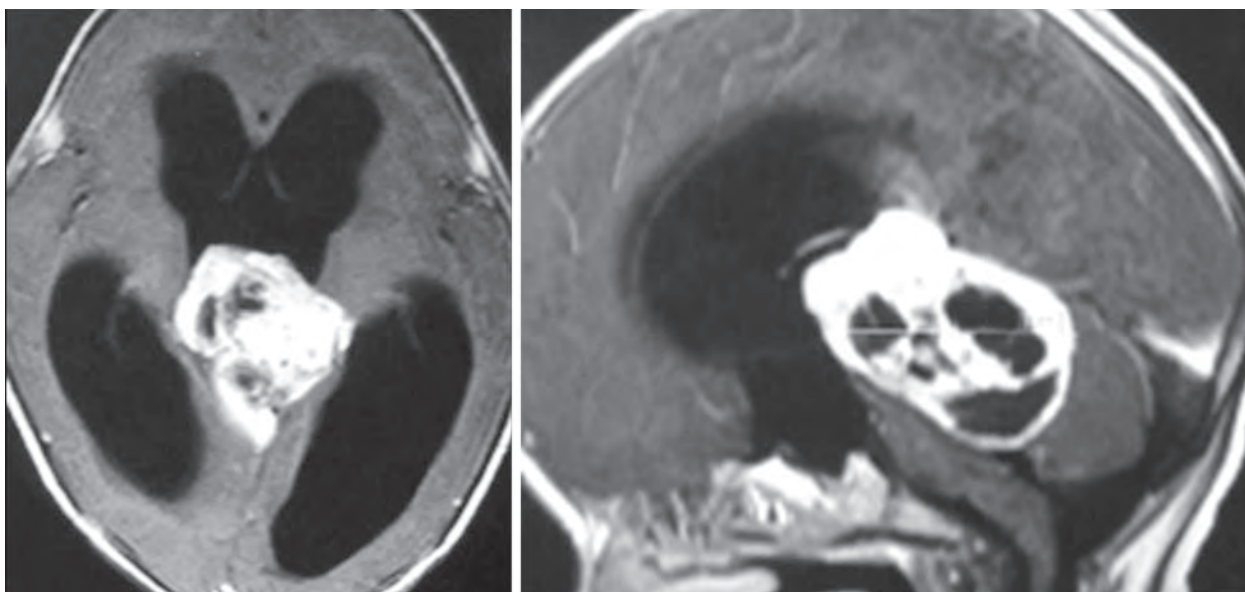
A 1¼ -year-old baby presented with vomiting and loss of walking ability. MRI showed a richly enhancing large mass in the pineal region with necrotic areas. The serum AFP was 225 ng/ml. Endoscopic third ventriculostomy and biopsy through a single burr hole showed a mixed malignant germ cell tumour with components of immature teratoma and endodermal sinus (yolk sac) tumour. The family refused definitive surgery or adjuvant therapy
